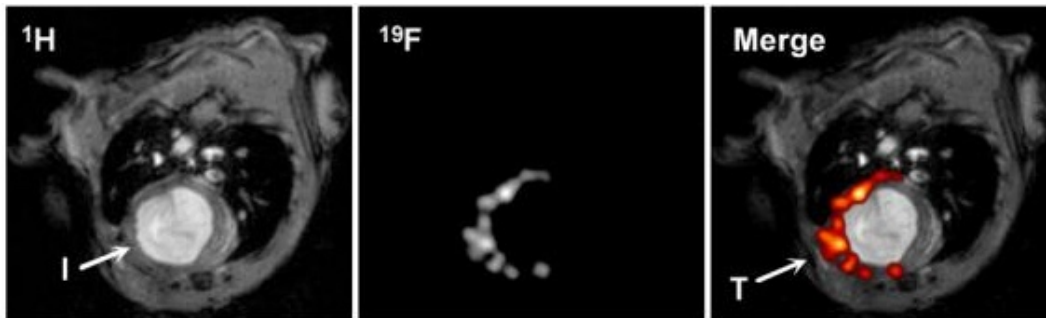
Infiltration of PFCs after myocardial infarction as detected by in vivo ^{19}F MRI as an example of merging imaging. Reprinted (adapted) with permission from [56]. Copyright 2008 Circulation.
